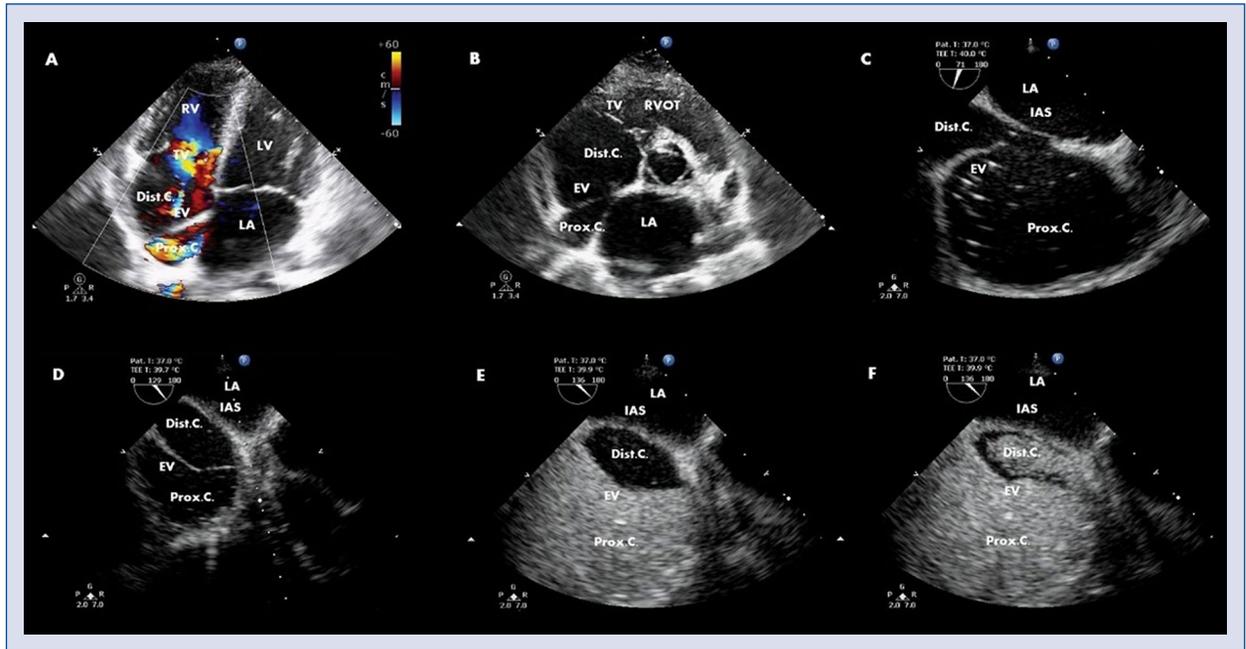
A. A large Eustachian valve divides the right atrium in two cavities (transthoracic echocardiogram [TTE] 4C); B. TTE SAX; C. Transesophageal echocardiogram (TEE) 70°; D. TEE 130°. Agitated contrast saline infusion initially fills the proximal right atrium (RA) cavity only; E. Later the contrast enters the distal RA cavity; F. Echo contrast free space between the two RA cavities represents the Eustachian valve (EV); LV — left ventricle; RV — right ventricle; LA — left atrium; Prox.C — proximal right atrium cavity; Dist.C — distal right atrium cavity; IAS — interatrium septum; TV — tricuspid valve.
